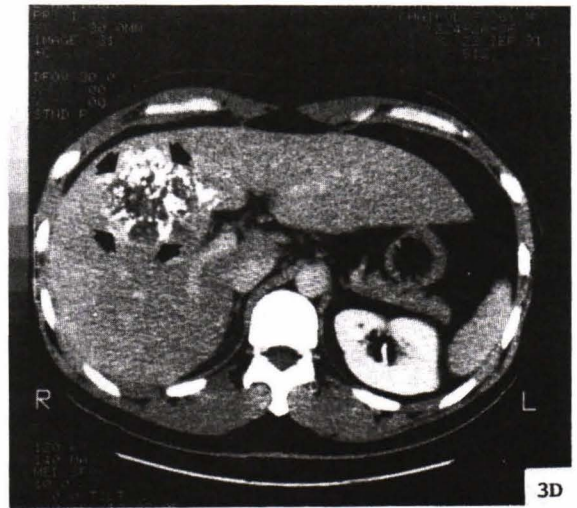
Same case as Fig. 3A, contrast enhanced CT scan after second TOCE prior to surgery shows decrease in size of HCC now technically feasible to be resected (arrow).
